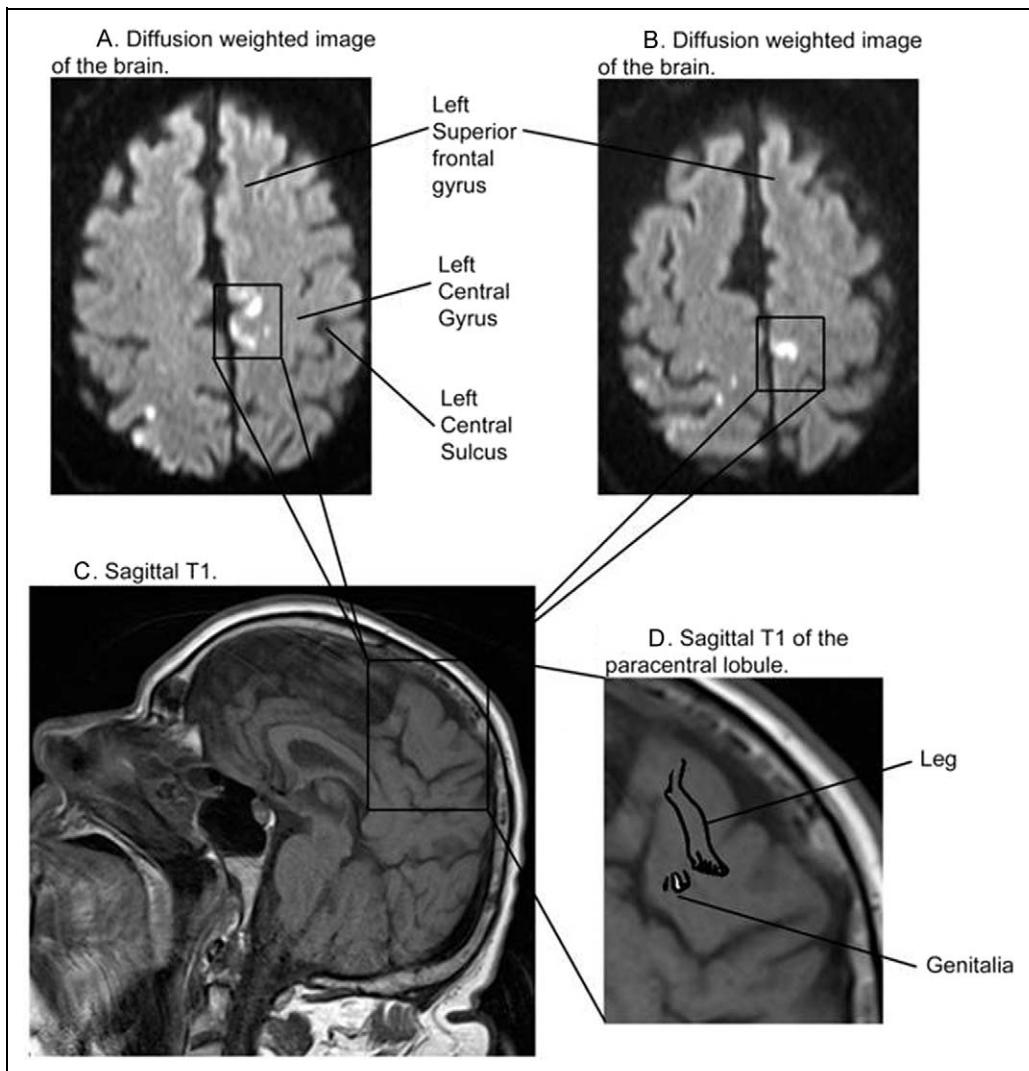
Magnetic resonance imaging (MRI) without contrast of the brain. Diffusion-weighted image axial demonstrating a hyperintensity in the left central gyrus (A and B). Corresponding sagittal T1 with enlargement of the paracentral lobule and overlaying homunculus depicting the leg and genitals (C and D).
